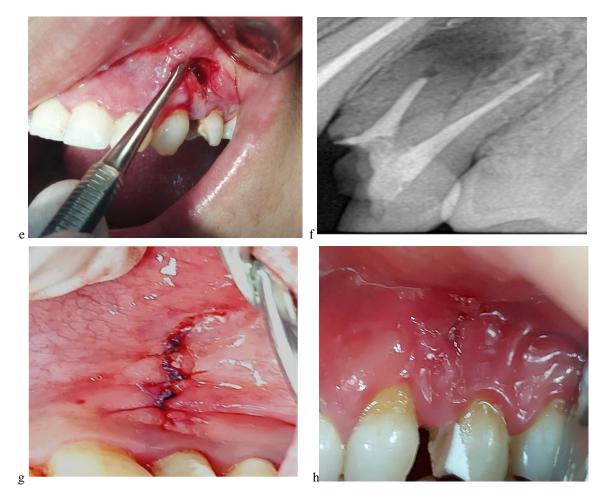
Intra-treatment Surgical procedure, a) check guide stability intraoral and mark site of incision, b) vertical incision, c) Single step osteotomy and root resection, d)trephine bur, e) Retro cavity through the osteotomy, f) radiograph to check the retro cavity preparation, g) suturing, h) after suture removal.
